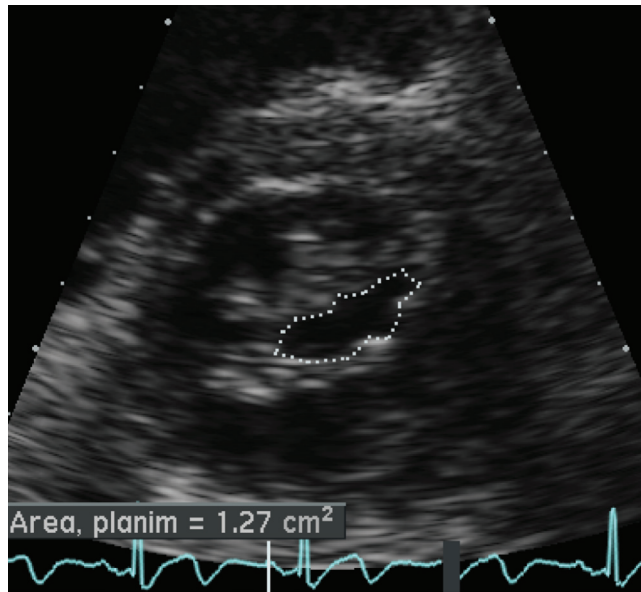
■ Parasternal short-axis view allows for direct planimetry of the valve opening in a patient with rheumatic mitral stenosis (area = 1.3 cm²).
